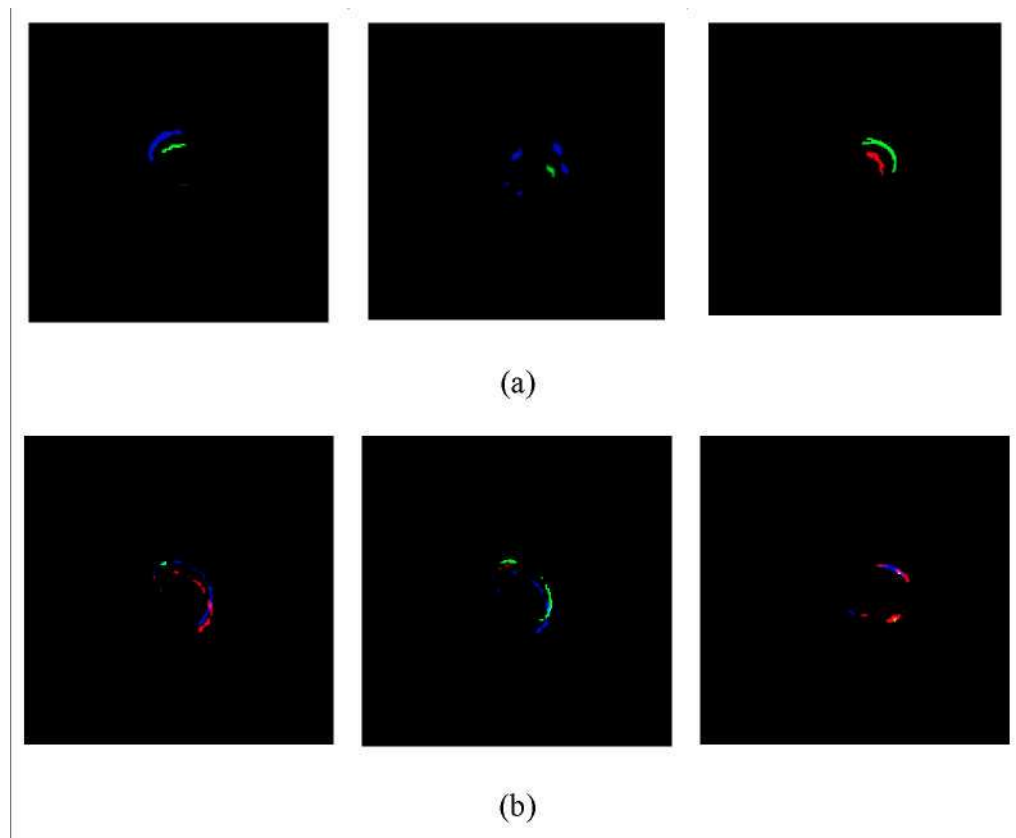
Analysis of Misclassifications in the Sequential Reconstruction of LGE-MRI Segmented Image:(a) Misclassifications of False Negative Caused By Large Anatomical Gaps Between Slices Resulting in Discontinuities and (b) Misclassifications of False Positives Caused by the Sequential Pattern of Healthy Tissue Resembling True Scar Tissue
